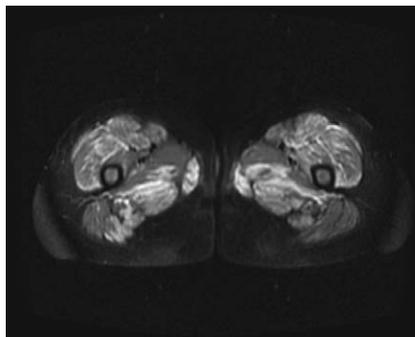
Fat-suppressed T2 MRI of patient at diagnosis. The bright areas reflect edema and inflammation in the quadriceps and hamstring muscles bilaterally.
